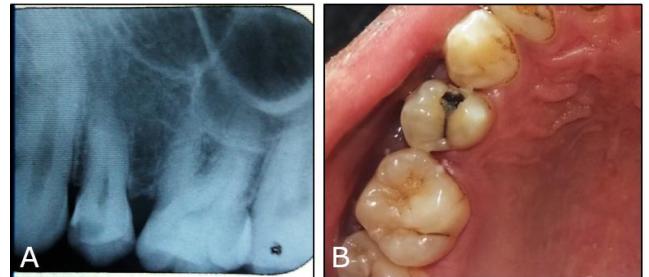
A): Periapical radiograph showing proximal caries; B): clinical picture
